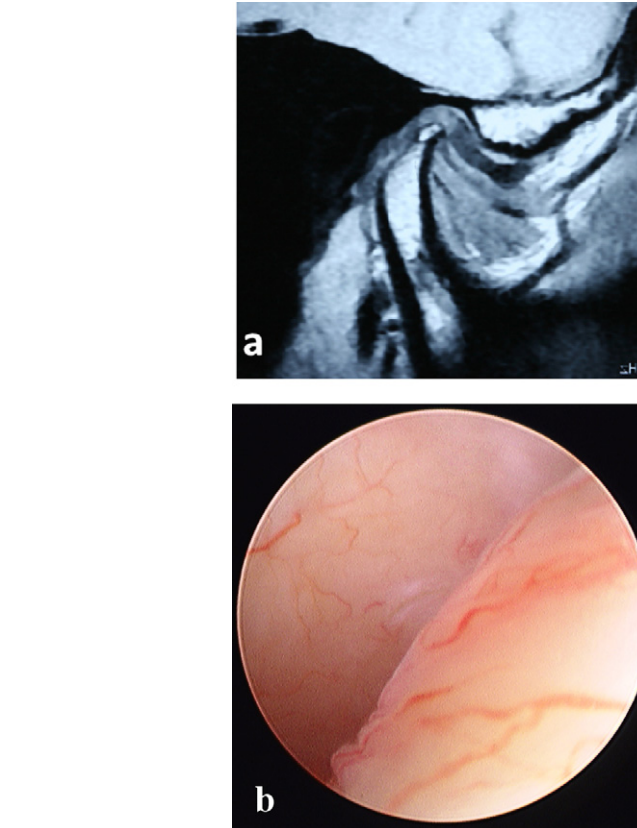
Anterior disc displacement is shown by: (a) preoperative sagittal MRI examination (closed mouth, T1-weighted image) and (b) arthroscopic view of the retrodiscal tissue in the posterior pouch for patients with disc displacement.
